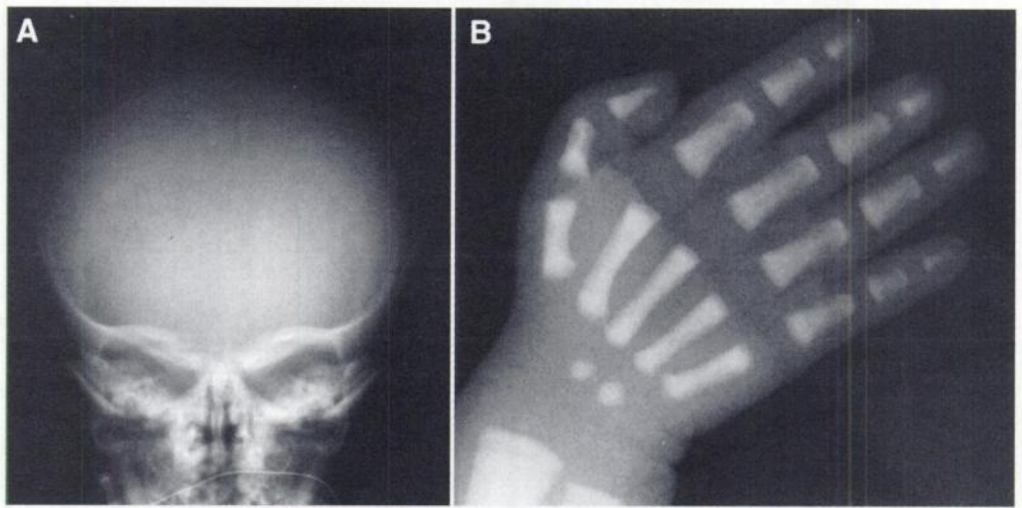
Radiograph images of (A) head and (B) right hand demonstrate typical bone sclerosis.
